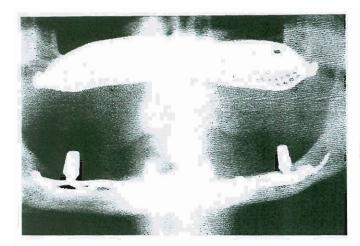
Case 3: Pre-operative radiograph reveals settling of the lower right posterior third and bone resorption beneath the left posterior abutment of an 11-year-old mandibular subperiosteal implant. The anterior segment of the implant remains normal and free of any problem.
